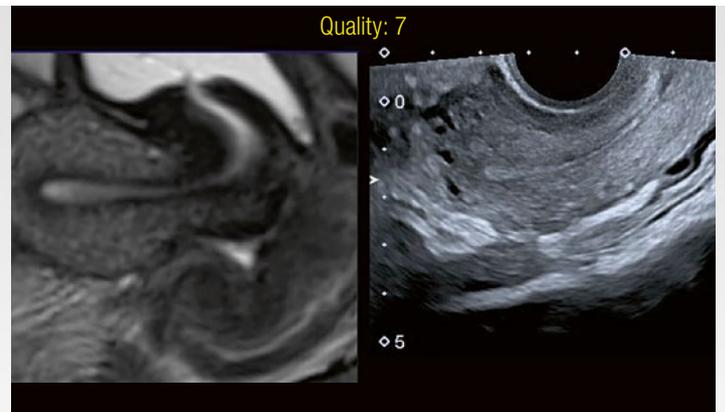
MRI and ultrasound sagittal section showing the quality score for detection by the probe (quality 7).
